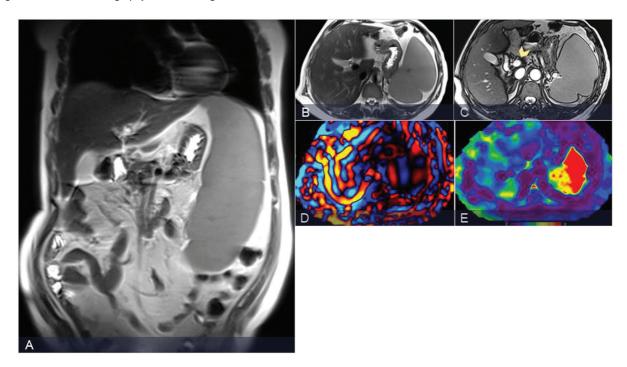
New-onset massive splenomegaly. (A) Coronal T2W MR shows massively enlarged spleen with differential diagnosis of CLD and myeloproliferative disease. (B) Axial T2 HASTE shows normal liver morphology. (C) Axial TRuFl image shows patent portal vein (arrowhead). (D) MRE wave image shows normal amplitude waves. (E) Stiffness map shows normal LSM of 2.4 kPa suggesting absence of chronic liver disease. Bone marrow biopsy later proved myelofibrosis which explained the splenomegaly. CLD, chronic liver disease; HASTE, half-Fourier single turbo spin-echo; LSM, liver stiffness measurement; MR, magnetic resonance; MRE, magnetic resonance elastography; T2W, T2-weighted.
